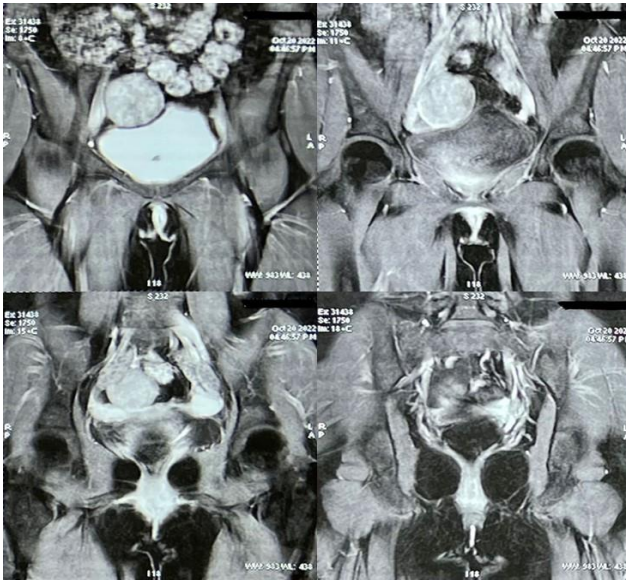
MRI showing uterine remnant bands with fibroids arising from them bilaterally. Ovaries present bilaterally.
